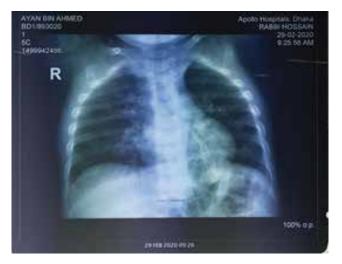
Posteroanterior view of chest radiograph at presentation showing Patchy opacities are noted in both perihilar
